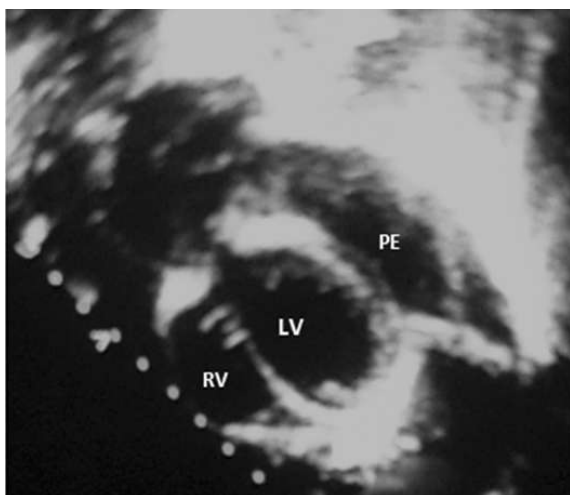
Echocardiography - subcostal four chamber view showing large pericardial effusion (PE), mostly around left atrium and left ventricle (LV)
